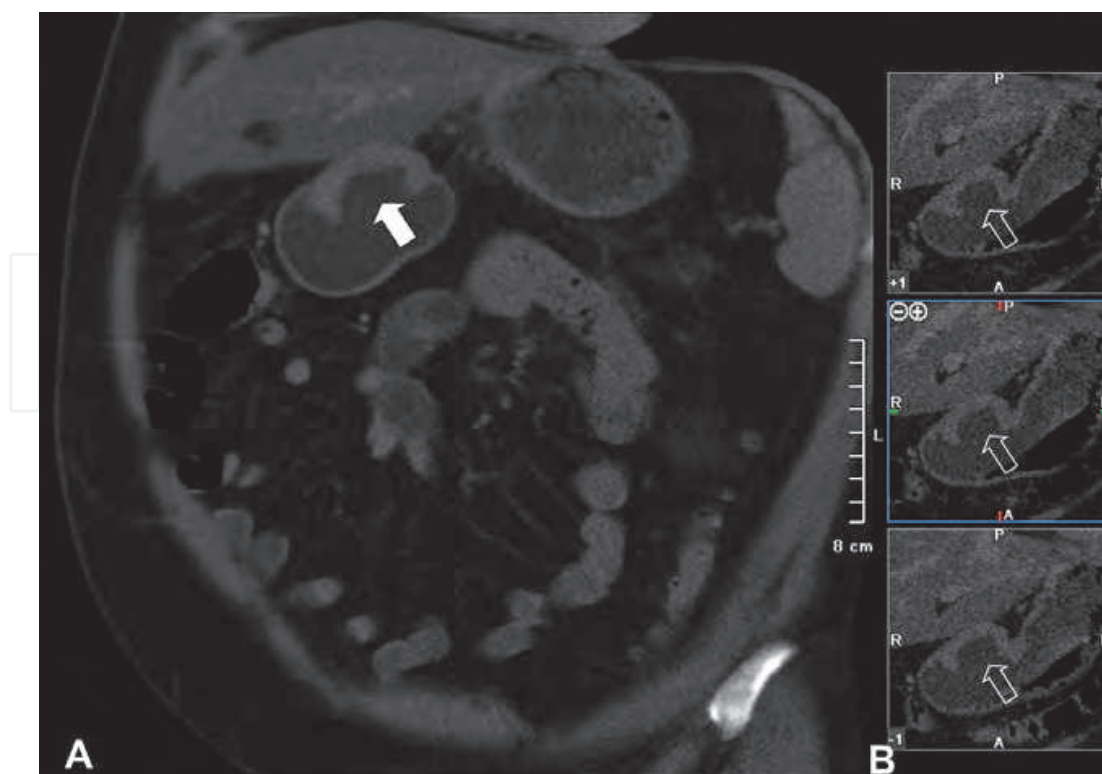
Gastric ulcerative carcinoma. Same patient as in Fig. 3. A. CT reconstruction on oblique coronal plane. The tumor appears as an ulcerating wall thickening (arrow). B. Vessel Probe reconstructions allow to obtain a better identification of the gastric wall in the lesion site (empty arrows).
